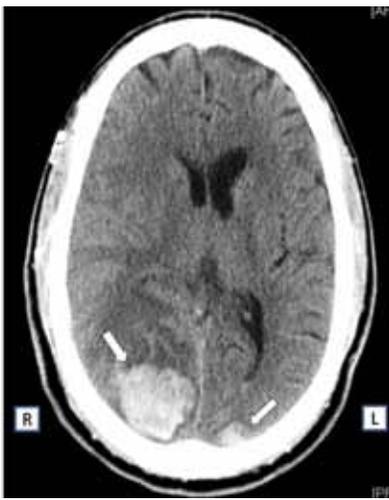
Head CT. Arrows: intracranial hemorrhage at bilateral occipital lobes.
